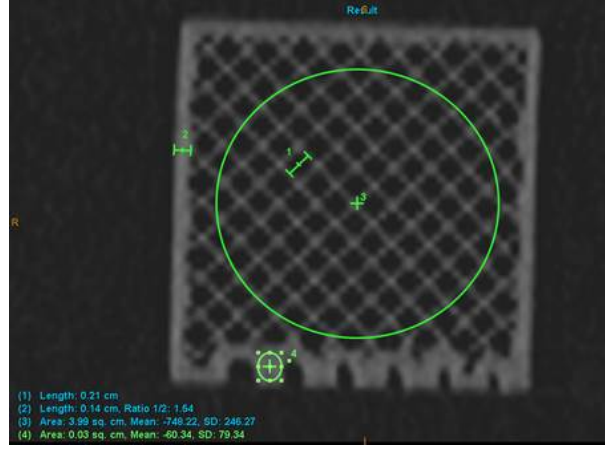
GE Lightspeed CT Scan of the 3D printed low density material, with acquisition settings of 120kV and 13mAs.
